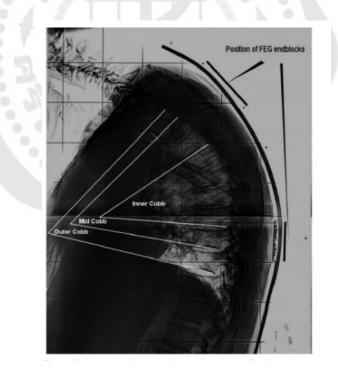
Radiography of thoracic cobb angle with flexible electrogoniometer endblocks
